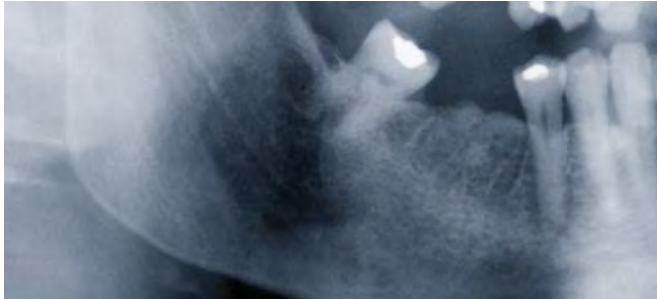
Radiographic appearance.
